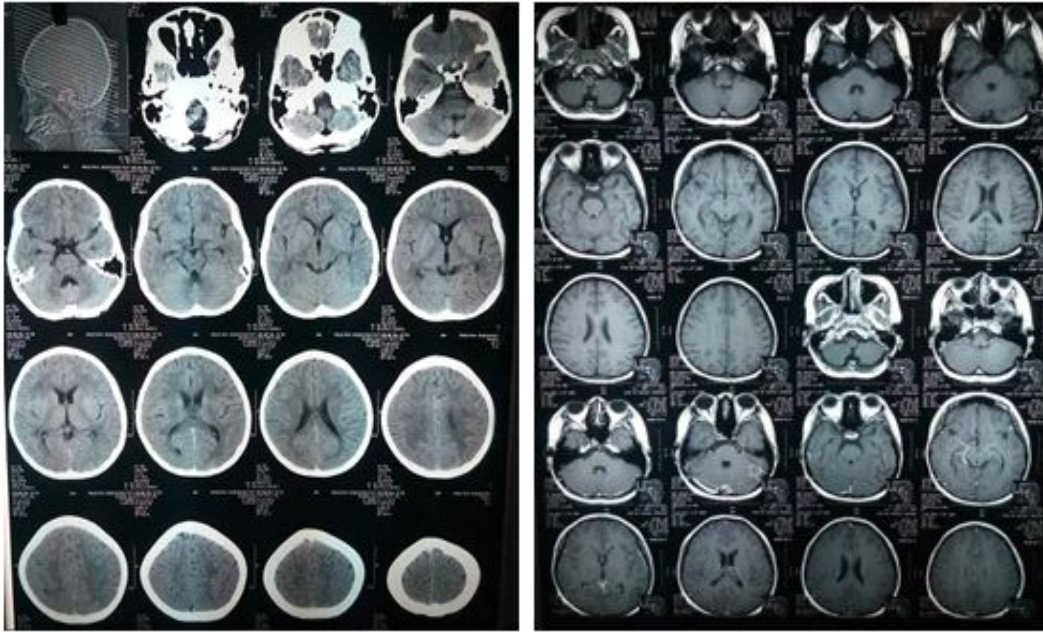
Brain MRI with contrast
